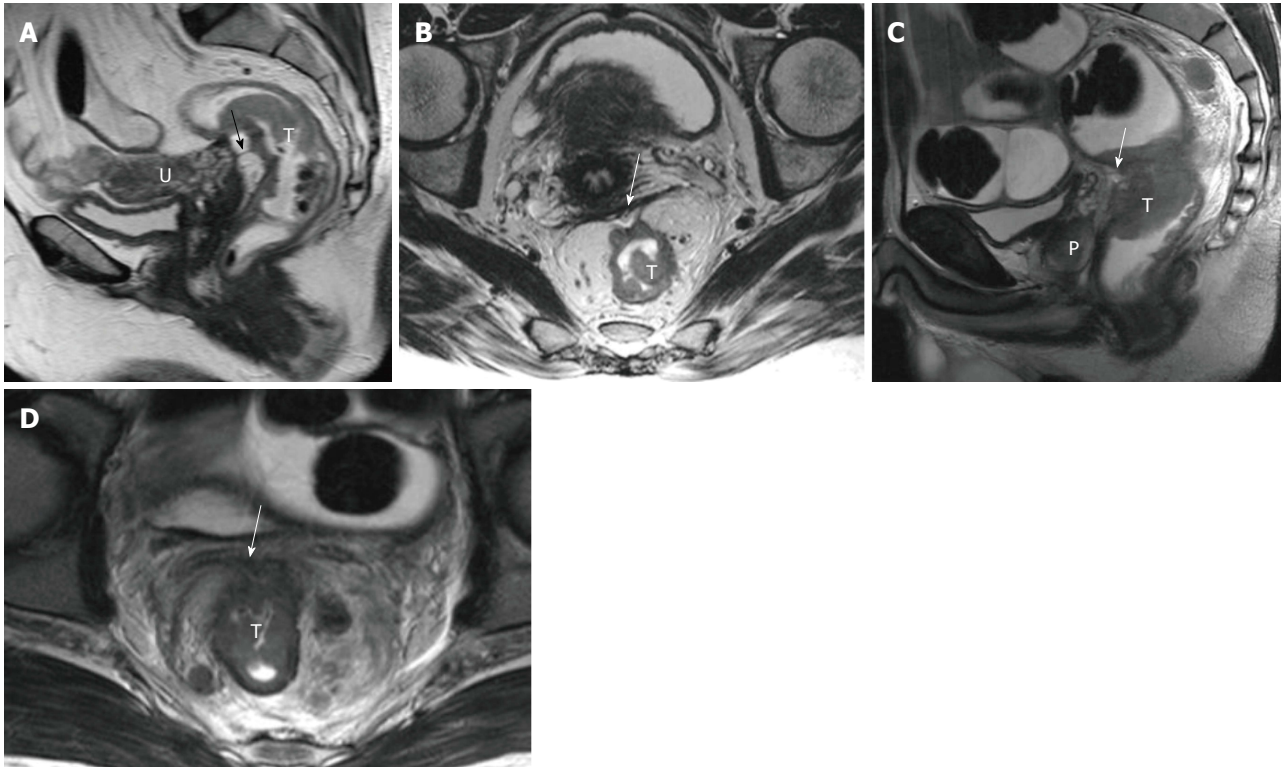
Periton invasion in female (A and B) and male (C and D) patients with T4a rectal tumors. On sagittal T2-weighted images, periton is seen as a hypointense linear structure in front of the tumor (arrows in A, C). On axial T2-weighted images, the peritoneum has a V shape and attaches onto the anterior aspect of the rectal cancer (arrows in B and D). T: Tumor; U: Uterus; P: Prostate.
